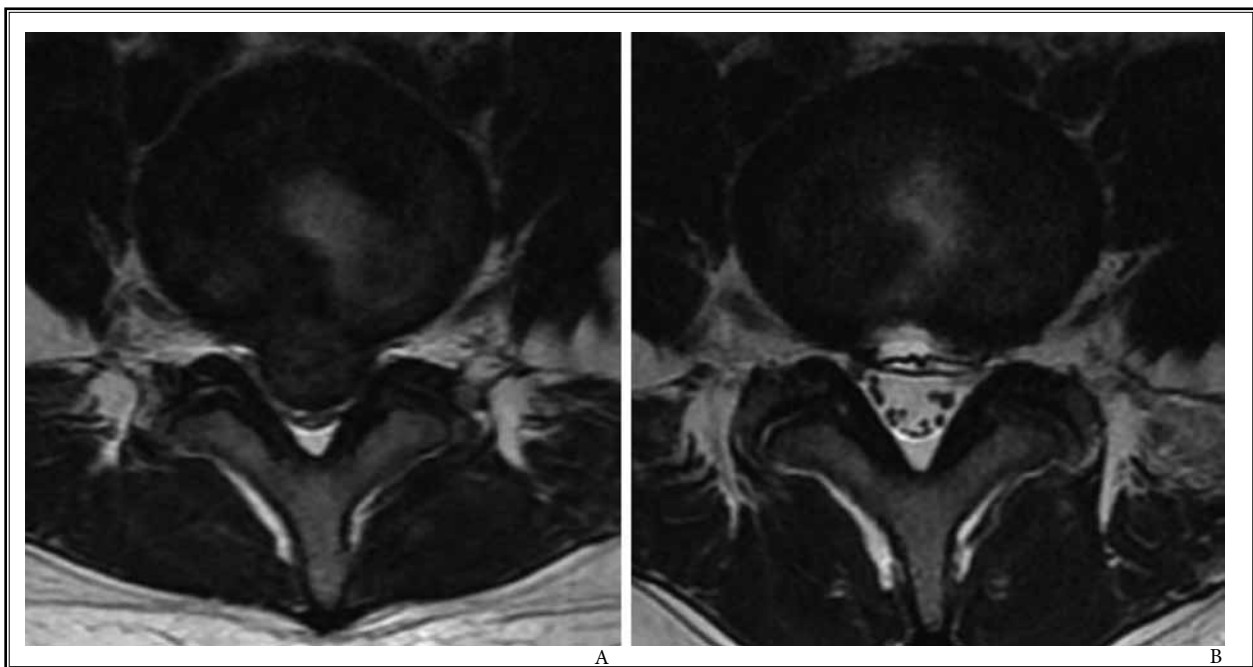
A 25-year-old girl presents with severe back and right leg pain due to large disc herniation at the L4-5 level. A: Preoperative MRI showing a large disc herniation covering the entire thecal sac. B: MRI showing complete removal of the herniated disc after percutaneous endoscopic lumbar discectomy.
